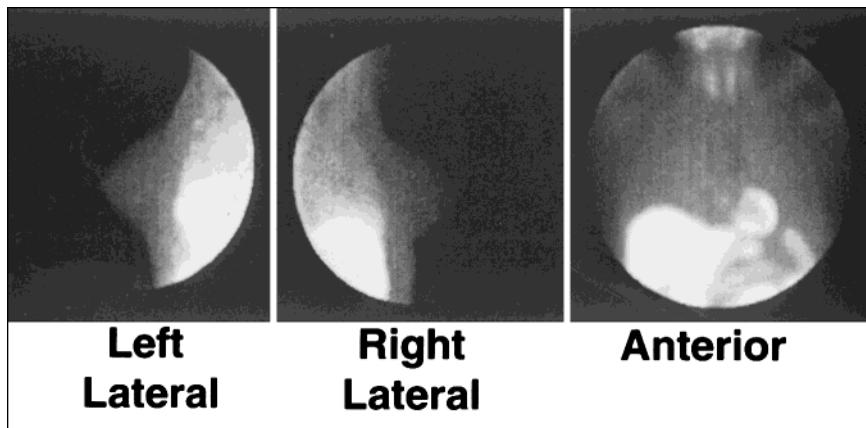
Example of normal breast scintigraphy images with optimal image quality. No focal areas of radiopharmaceutical uptake are seen in the breasts nor in the axilla.
